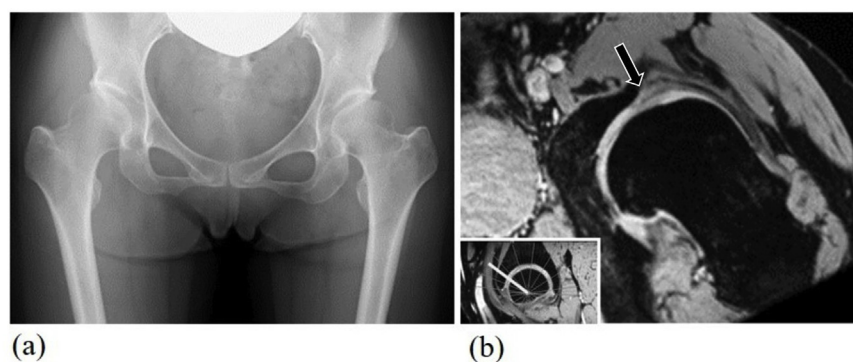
Plain radiograph and magnetic resonance image (MRI) for case 3, showing (a) acetabular dysplasia on the plain radiograph, and (b) the labrum tear (arrow), in an anterolateral position, on MRI.
